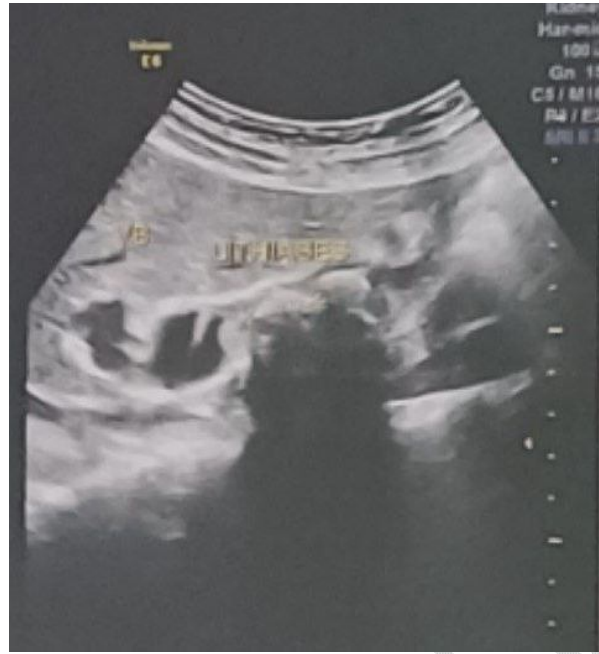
An ultrasound image of the lithiasis gallbladder
